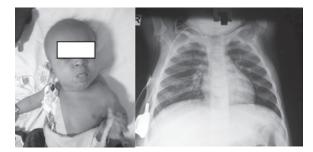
A child with cancer having portocath and X-ray showing it in position
